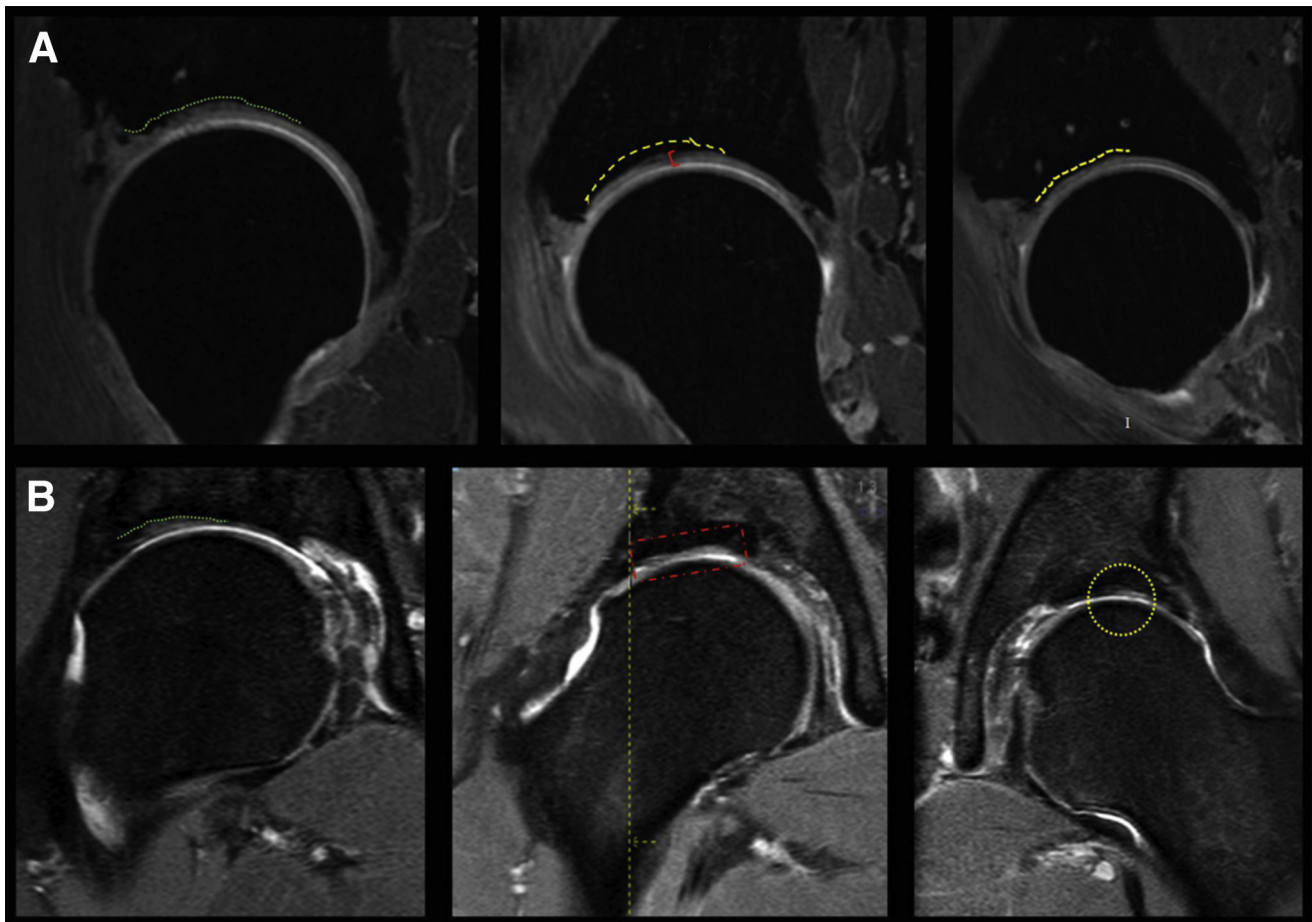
Right hip cellular collagen matrix implantation (AMIC) technique assessment by means of 3T magnetic resonance imaging (MRI) arthrography, manual decoaptation, and traction. (A) Left image, prior chondral defect filling, subchondral lamina abrasion, and central and right images, AMIC implant isointense to the adjacent tissue, homogeneous, aligned with satisfactory subchondral integration; (B) From left to right, tissue of the aligned AMIC implant, covered acetabular defect, signal of the generated tissue similar to the adjacent chondral tissue.
